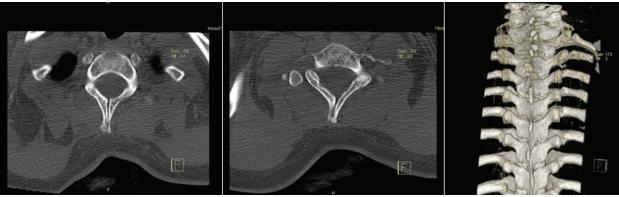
CT axial bone window and VRT images demonstrating spina bifida occulta of 7th cervical and 1st dorsal vertebrae.
